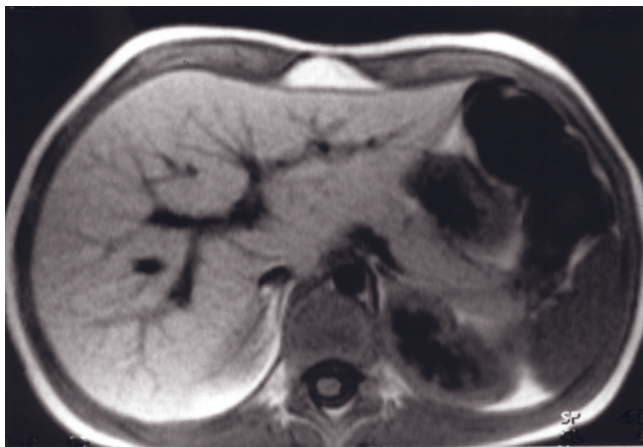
(Continued) 1.5-min gadolinium-enhanced T1-weighted fat-suppressed spin-echo (b), 5-min gadolinium-enhanced T1-weighted fat-suppressed spin-echo (i), and transverse (j) and sagittal (k) T2-weighted single-shot echo-train spin-echo images. Images of the abdomen are acquired first, pre- and postgadolinium (a-b), followed by imaging of the pelvis (i-k). In sedated patients, a combination of longer duration, breathing-averaged sequences (c-e, b, i) and breathing-independent single-shot techniques (a, b, f, g, j, k) are used. In this patient the T2-weighted images of the pelvis were acquired with single-shot technique. If there was a high index of suspicion of pelvic disease, breathing-averaged sequences could have been performed. Note the excellent demonstration of the pancreas on the noncontrast breathing-averaged fat-suppressed T1-weighted spin-echo images (d, e).
